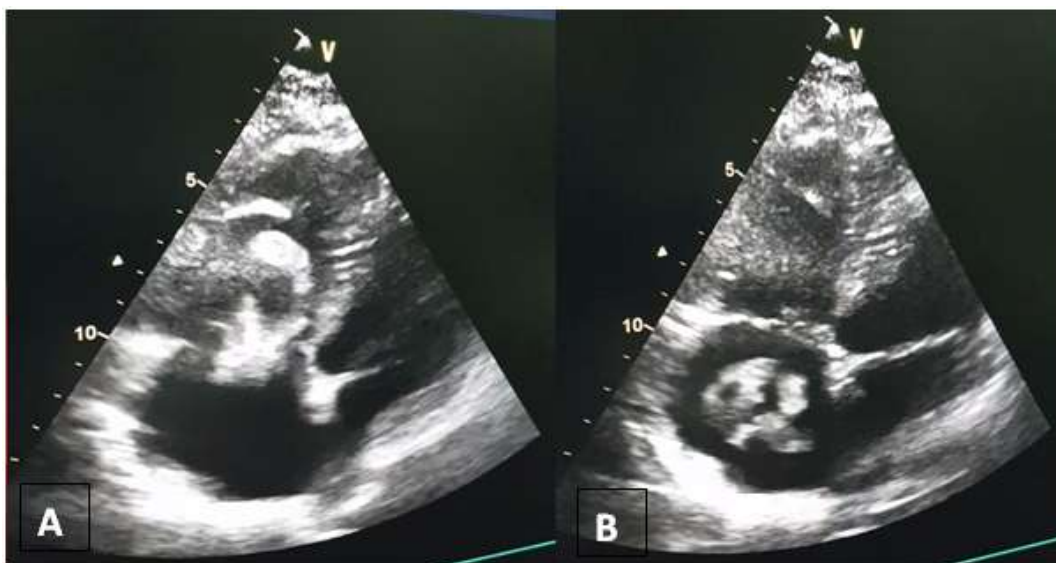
A transthoracic echocardiographic image; apical four- chamber view showing numerous mobile thrombi in the prolapsing right atrium in the right ventricle in diastole (A), a dilatation of right chambers and a voluminous heterogeneous, polylobulated horseshoe-shaped mass, in the right atrium in systolic (B).
